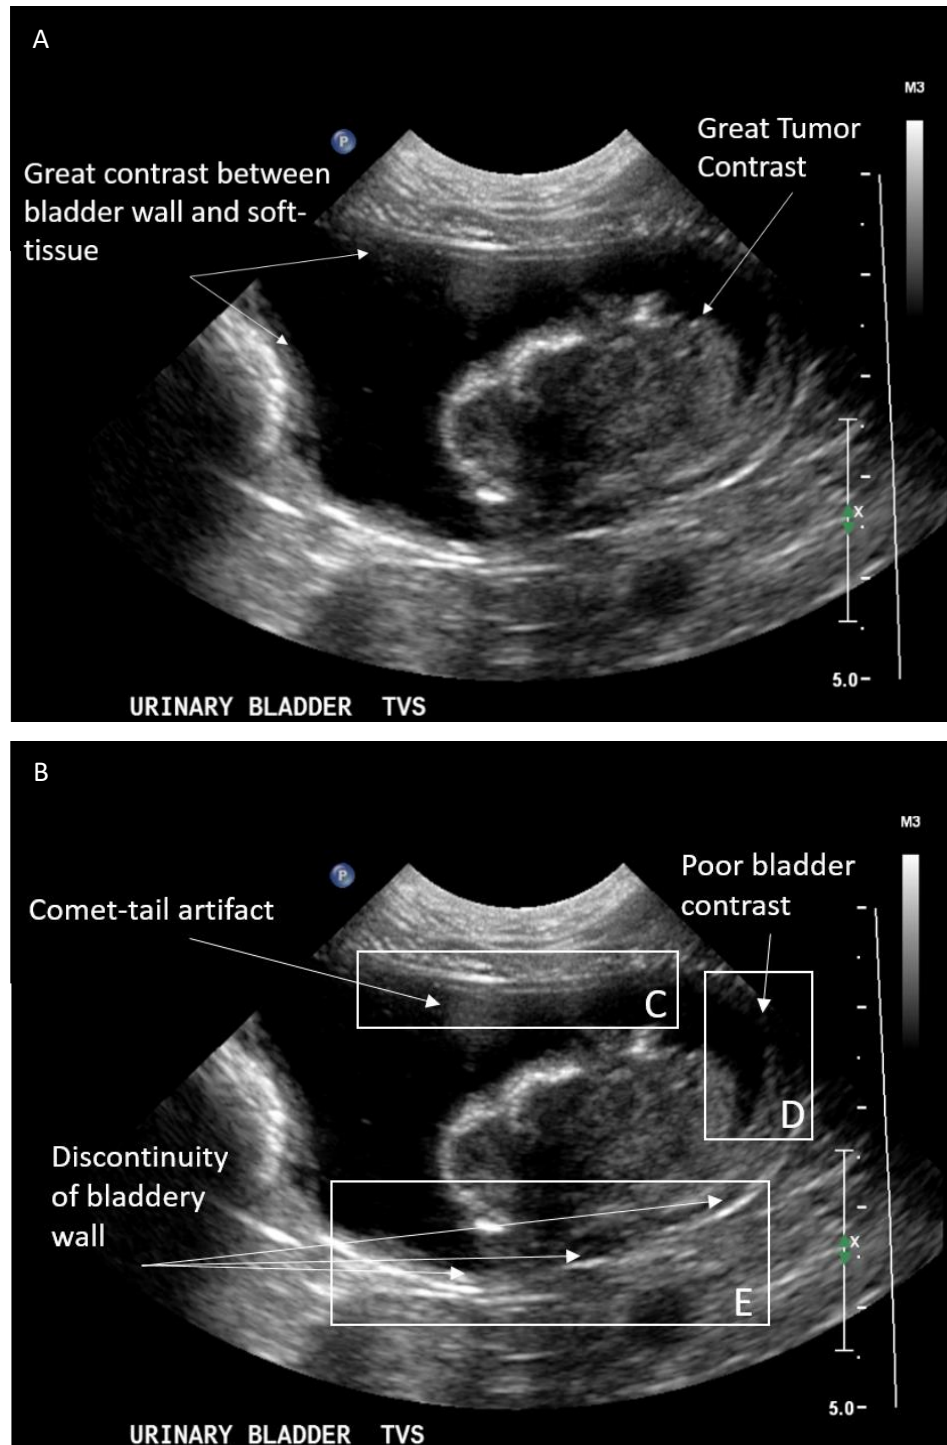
Ultrasound TCC image. A) Highlighting good bladder and tumor contrast. B) Highlighting reverberation (C), refraction (D) and speed of sound displacement (E).
